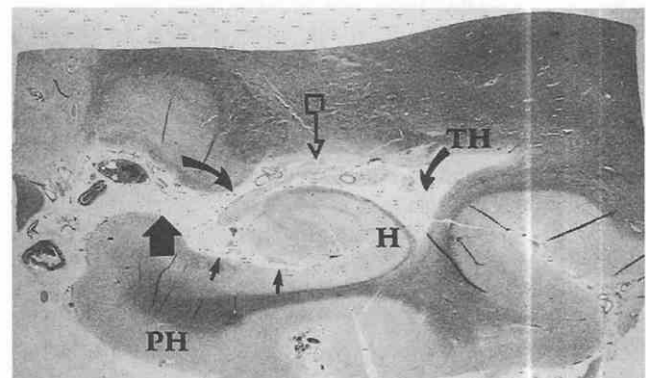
Normal anatomy of the brain Coronal pathologic section through the medial temporal lobe, including the hippocampus (H). The perihippocampal fissures, including the transverse fissure of Bichat (large arrow), the hippocampal fissure (small arrows), and the choroidal fissure (curved arrows) are seen. The transverse fissure of Bichat communicates with the perimesencephalic cistern (lower left). The choroid plexus and the fimbria (arrow with square) form a physical barrier between the temporal horn (TH) and the choroidal fissure. PH, parahippocampal gyrus. (From Holodny AI, George AE, Golomb J, et al: The perihippocampal fissures: Normal anatomy and disease states. Radiographics 18:653-665, 1998.)
